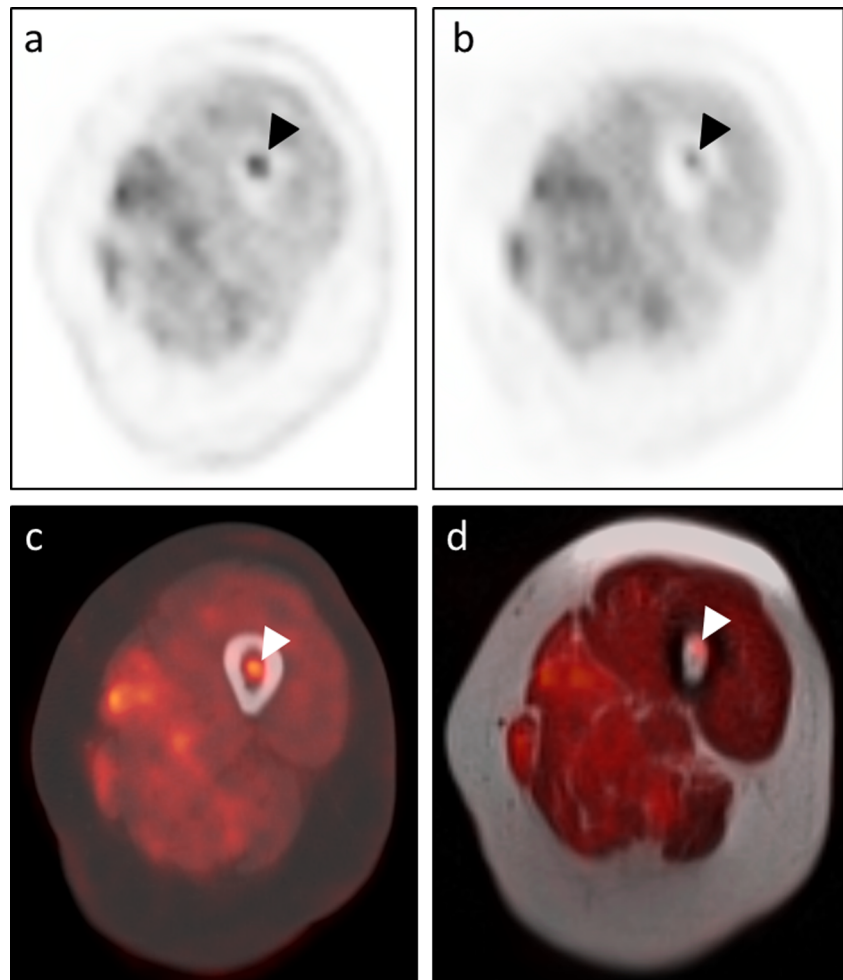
FFBL deemed more conspicuous on PET images from PET/CT dataset by both readers. An 81-year-old woman with recurrent retroperitoneal liposarcoma presented for restaging and underwent both PET/CT (a – transaxial PET images; c – transaxial CT images with PET fusion) and PET/MRI (b – transaxial PET images; d – transaxial T2W HASTE images with PET fusion). Among multiple other lesions, an FFBL within the marrow space of the proximal left femoral diaphysis (arrowhead) was selected for analysis. Both readers judged this lesion to be more conspicuous on the PET images from PET/CT (a) than on the PET images from PET/MRI (b). Note the dense cortical bone surrounding the lesion on the CT images (c). Neglecting cortical bone in the segmentation-based AC algorithm used for the PET images from PET/MRI likely contributed in this substantial difference in FFBL conspicuity (b)
